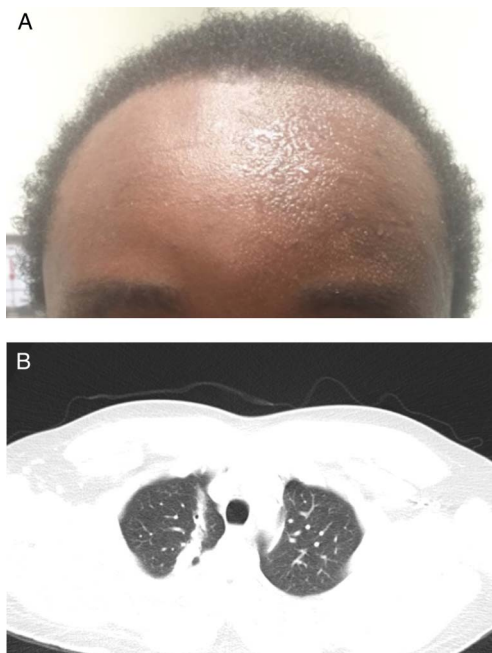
(A) Picture showing evidence of right-sided facial anhidrosis and left-sided hyperhidrosis with flushing. (B) CT-chest showing the presence of consolidation (likely fibrosis) related to the trajectory of the prior gunshot wound.
